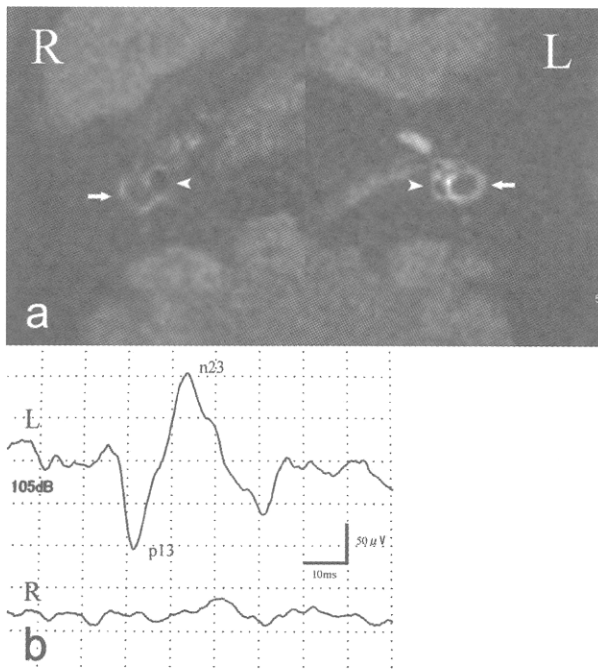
MRI imaging in patient no. 6 (definite Meniere's disease). The endolymphatic space in the saccules is detectable as a black area inside the perilymphatic space filled with gadodiamide in the vestibule (arrowheads). In the normal side (L), the endolymphatic space in the saccules is also detectable in the unaffected side, but is smaller than in the affected area. Arrows indicate lateral semicircular canals. In the affected side (R), enhancement by gadodiamide was weaker than in the unaffected side, indicating that endolymphatic hydrops may be present in the canal. VEMP testing showed no response in the affected side.
